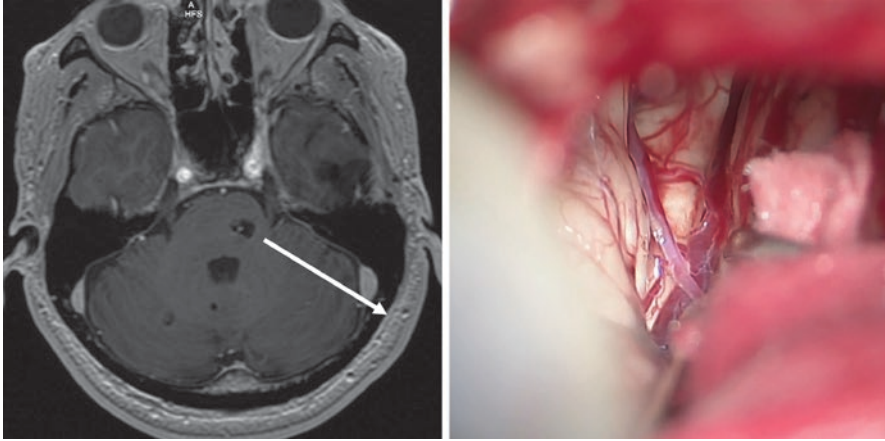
Cavernous malformations residing in the lateral aspect of the pons are safely approached through the middle cerebellar peduncle (MRI left). Projecting this trajectory back onto the skull suggests that a retrosigmoid craniotomy is best suited for resecting this lesion. Opening the petrosal fissure of the cerebellum (right) establishes a more posterior entry point into the MCP, allowing for a more favorable trajectory into the brainstem. Used with permission from Barrow Neurological Institute
